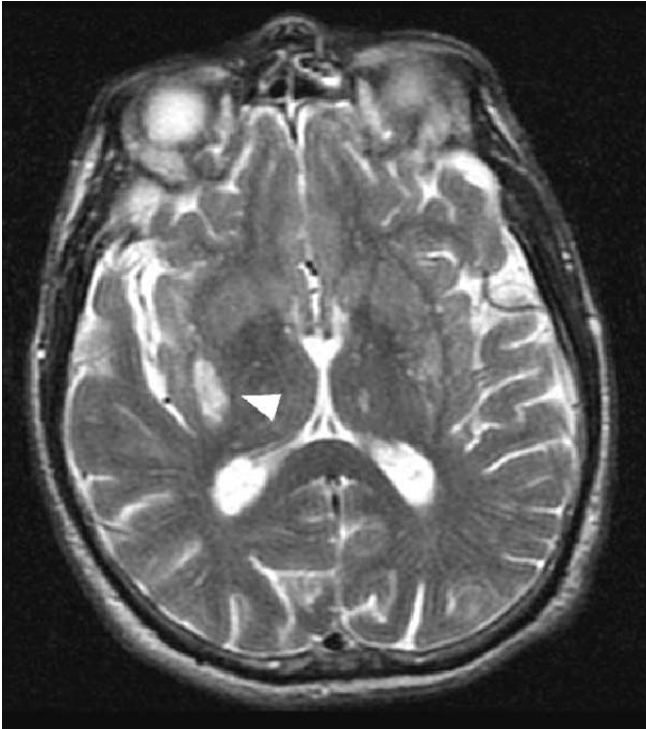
Magnetic resonance T2-weighted axial image showing an ischaemic area in the posterior region of right basal ganglia (*white arrowhead*)
